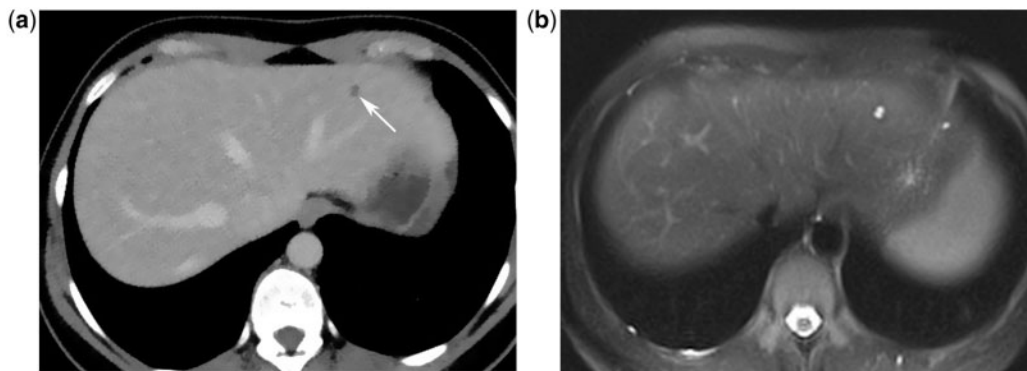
Lesion TSTC. Contrast-enhanced MDCT (a) shows a small lesion in the left lobe, which cannot be characterized. In a patient with a history of malignant disease, further work-up is recommended. The T2-weighted MR image (b) shows the tiny lesion to be very hyperintense, suggestive of a small cyst. Another tiny cyst is shown in the left lateral segment.
